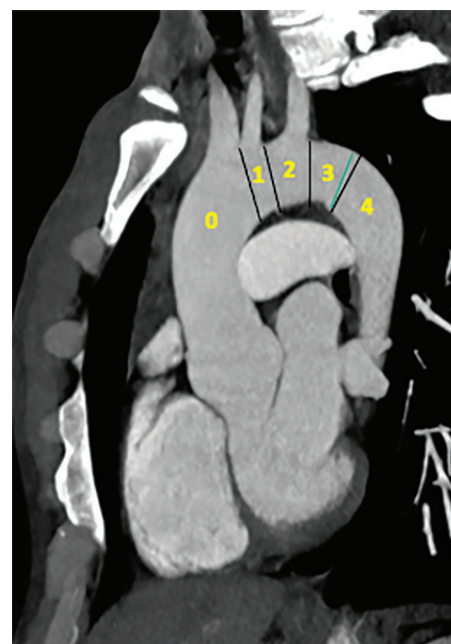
Oblique sagittal MIP CT image shows the aortic zones as defined by Criado et al (25).
